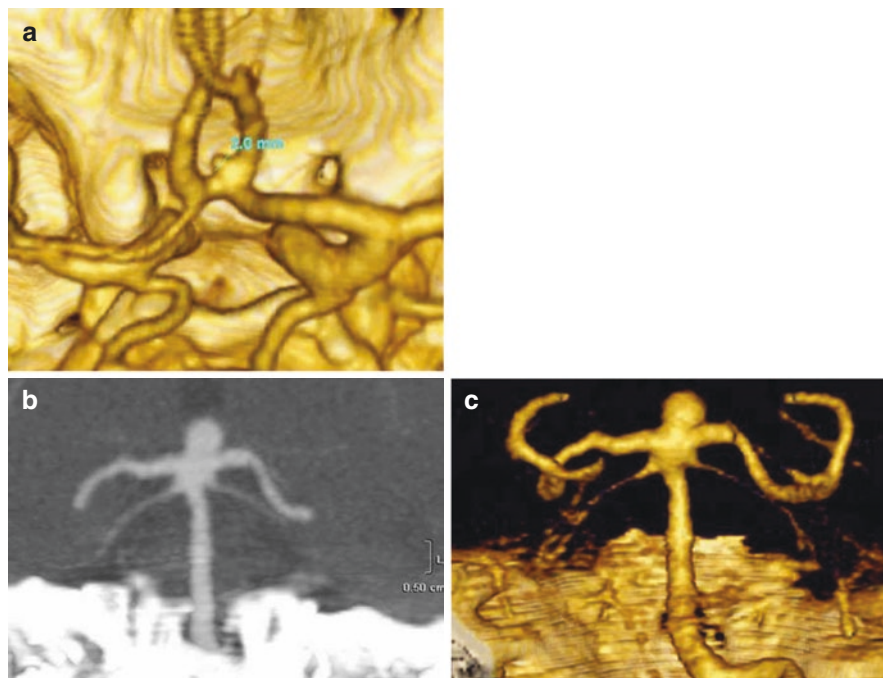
(a) Anterior communicating artery aneurysm. A small, 2-mm anterior communicating artery aneurysm is well visualized in this patient with prior subarachnoid hemorrhage (SAH) and “negative” cerebral angiography. (b) Basilar tip aneurysm on CT angiography with reconstruction (c)
